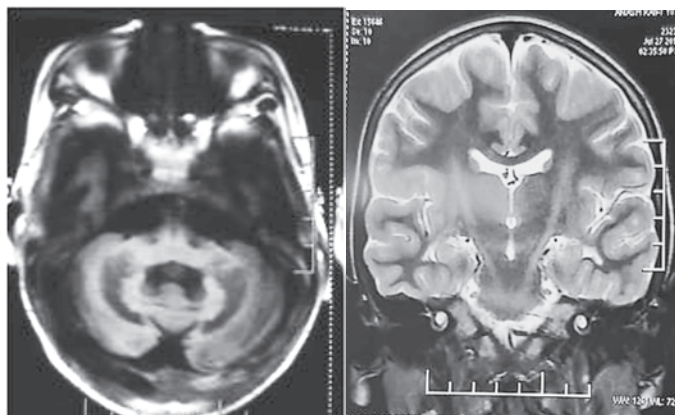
a&b. MRI image shows signal changes in bilateral dentate nuclei, Cortico-spinal tract involvement
